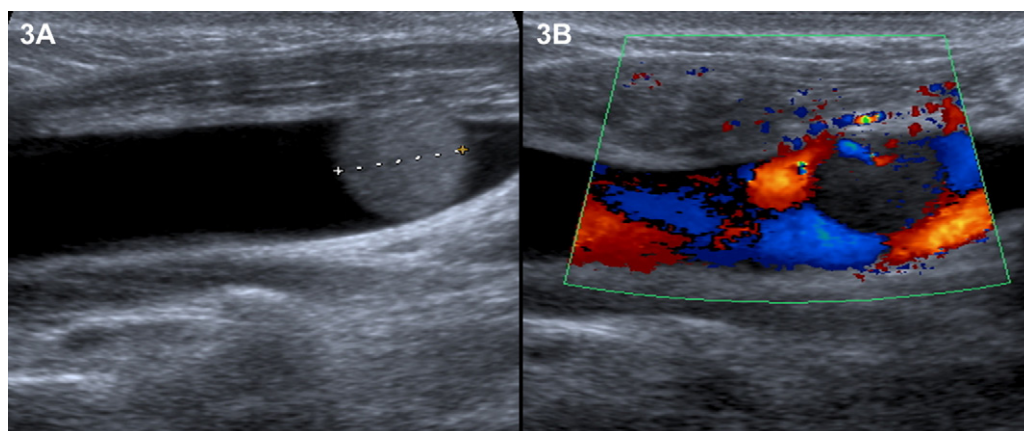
(A) Ultrasound image of the 10 mm pedicled spherical lesion within the RIV. (B) Ultrasound image showing pedicled lesion obtaining blood supply from adjacent tissues.
